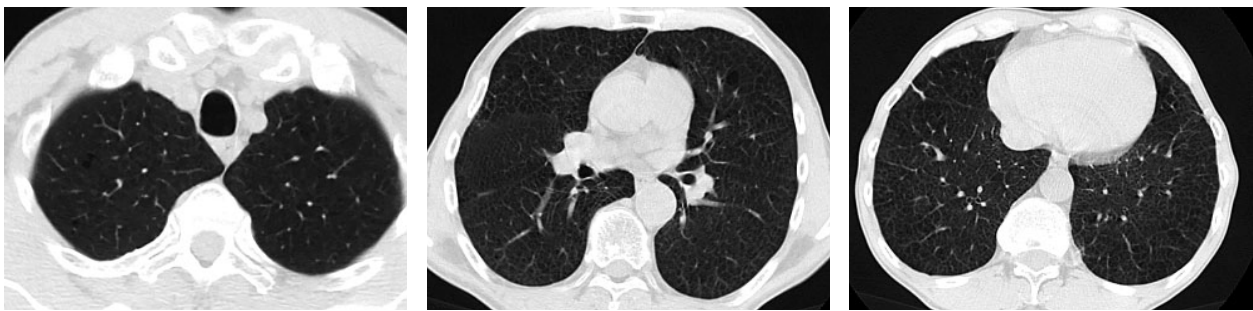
Computed tomography of the chest cavity dated 06.06.2023 (1 month after discharge)
